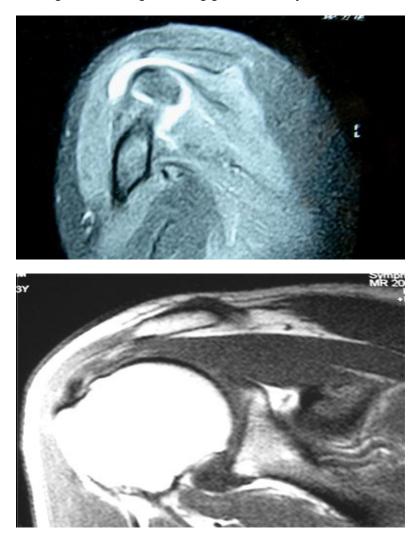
MRI image showing partial supraspinatus tear with SASD bursal effusion
